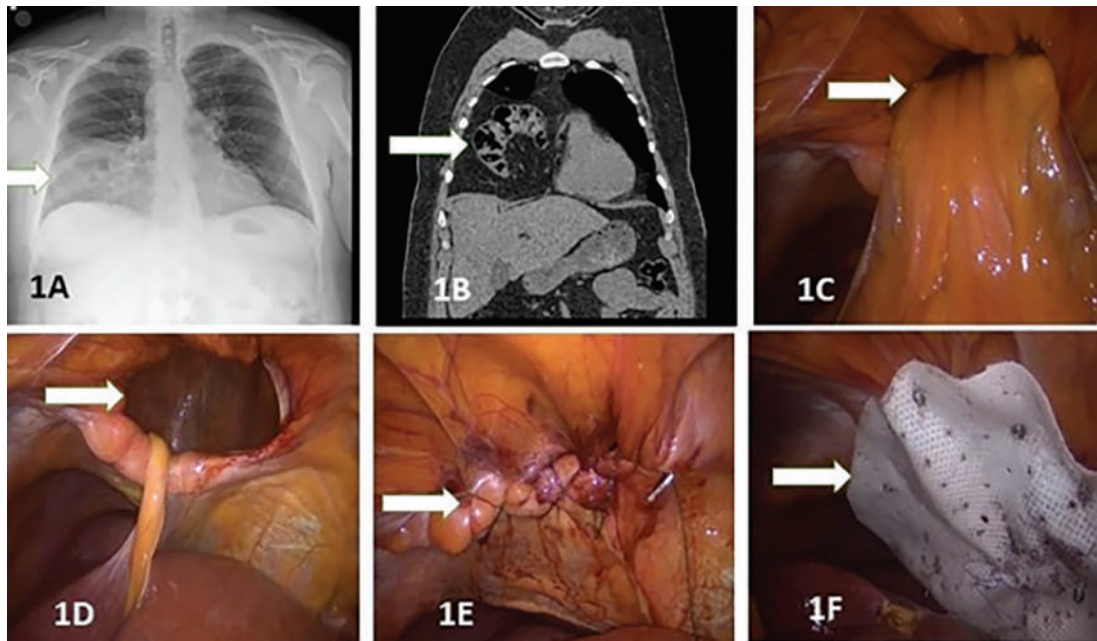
Radiological and intraoperative images. (A) Posterior–anterior chest radiograph showing an opacity in the right lower lung zone suspicious for a mass or consolidation; (B) thoracic computed tomography demonstrating herniation of a colonic segment into the thoracic cavity through a right diaphragmatic defect; (C) intraoperative laparoscopic view showing the diaphragmatic defect and herniated omentum; (D) reduction of the herniated omentum and colon into the abdominal cavity; (E) primary suturing of the diaphragmatic defect; (F) final view after reinforcement of the diaphragmatic repair with dual mesh.
